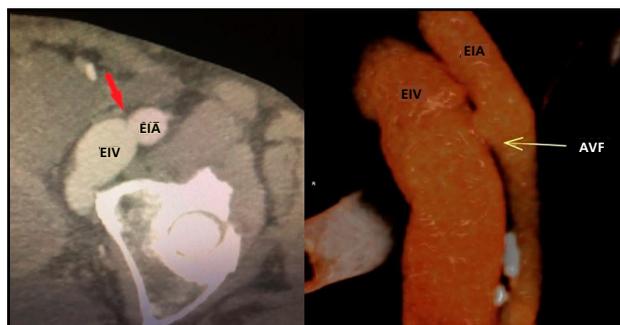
CT angiography: arteriovenous fistula (AVF) with dilation of external iliac (EI) vessels.
